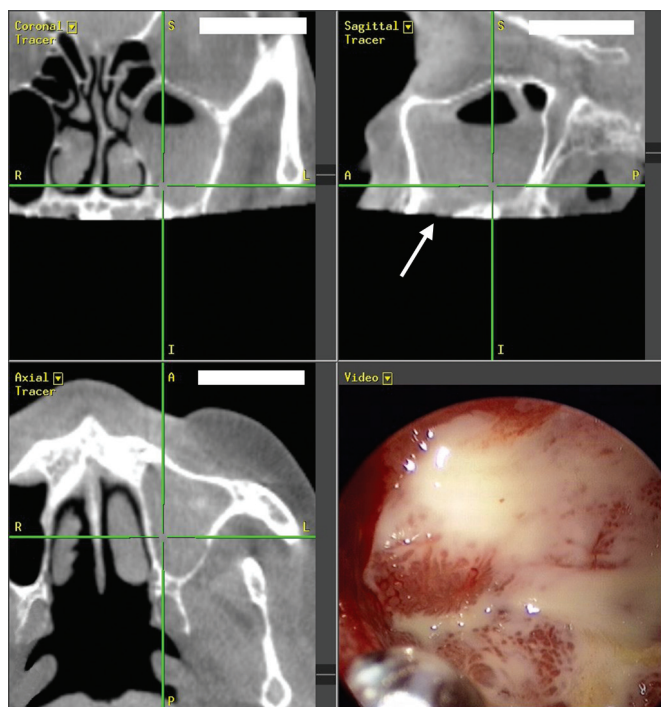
Odontogenic sinusitis. Computed tomography images demonstrate left maxillary sinusitis resulting from an infection of the maxillary dentition. The arrow points to the bony dehiscence in the floor of the maxillary sinus at the location of the now extracted infected tooth. On endoscopic view, retained purulent secretions are noted within the left maxillary sinus.
